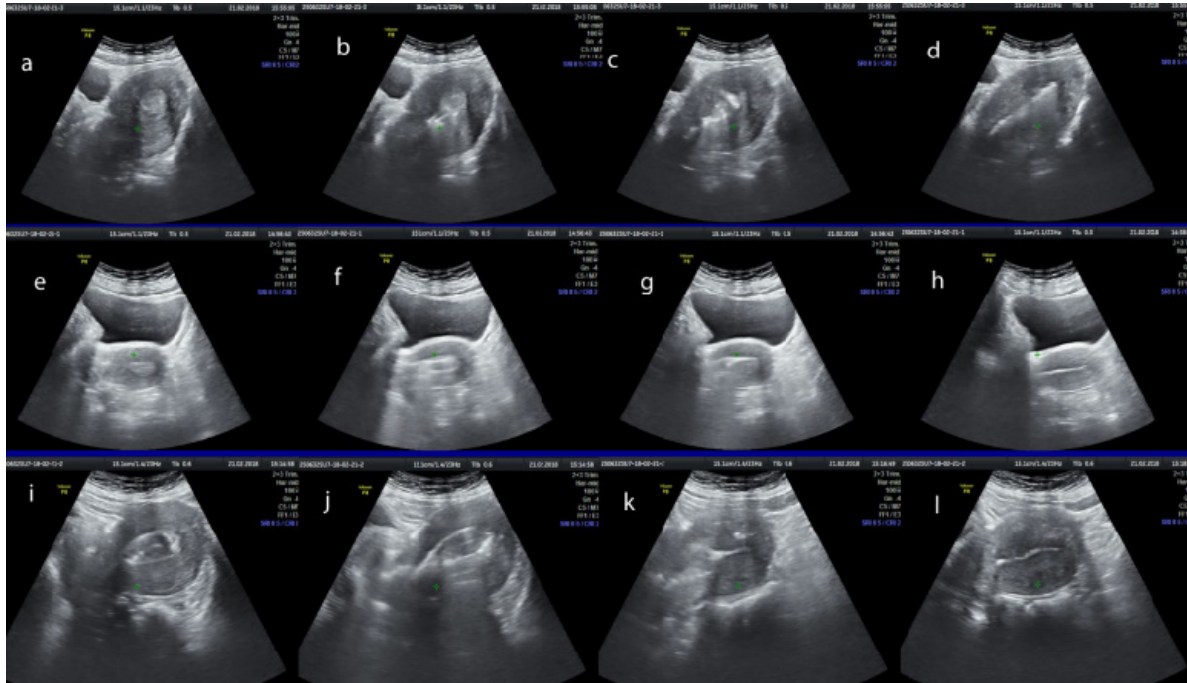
Ultrasonography view of patients during surgery. Preoperative (a, e, i), retention of endometrial pathologies with ring forceps (b, f, j), rotation and traction (c, g, k) and postoperative endometrial cavity (d, h, l)
